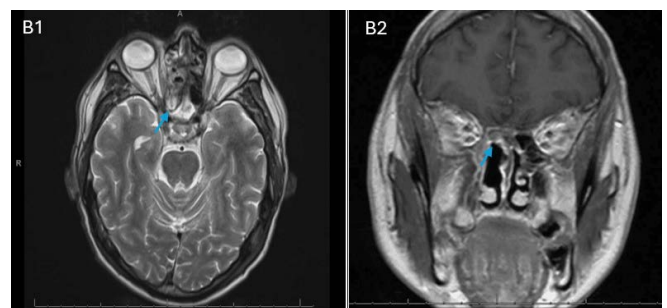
Axial (B1) and sagittal (B2) views of MRI brain post-chemotherapy with previous frontal craniotomy changes, with rim enhancing signal abnormality involving the frontal sinuses and extending to the superior margin of the ethmoid air cells measuring 2.3x4.4cms.
